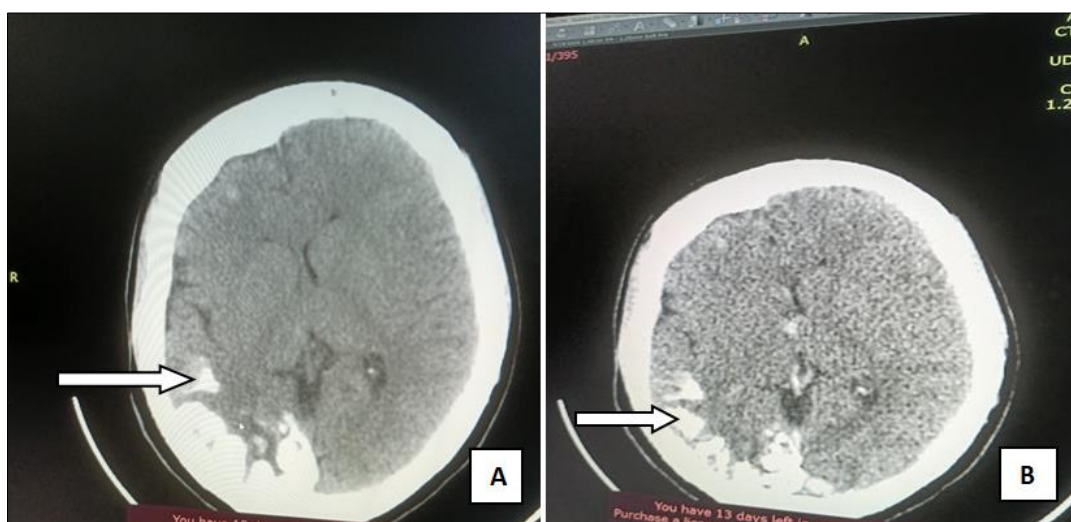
Non contrast computed tomogram (A) and contrast enhanced computed tomogram (B) of the brain showing areas of non enhanced gyral hyperdensity (HU = 126) in the right cerebral hemisphere (arrows)
